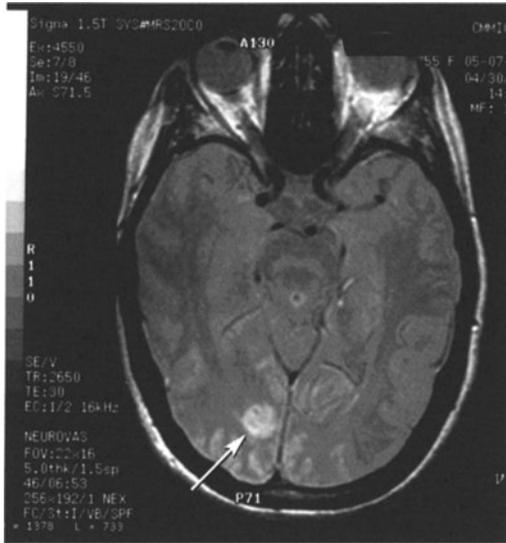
Infarct right occipital area, calcarine artery branch territory (Embolus to posterior cerebral artery from heart). MRI. Case 26-5.
